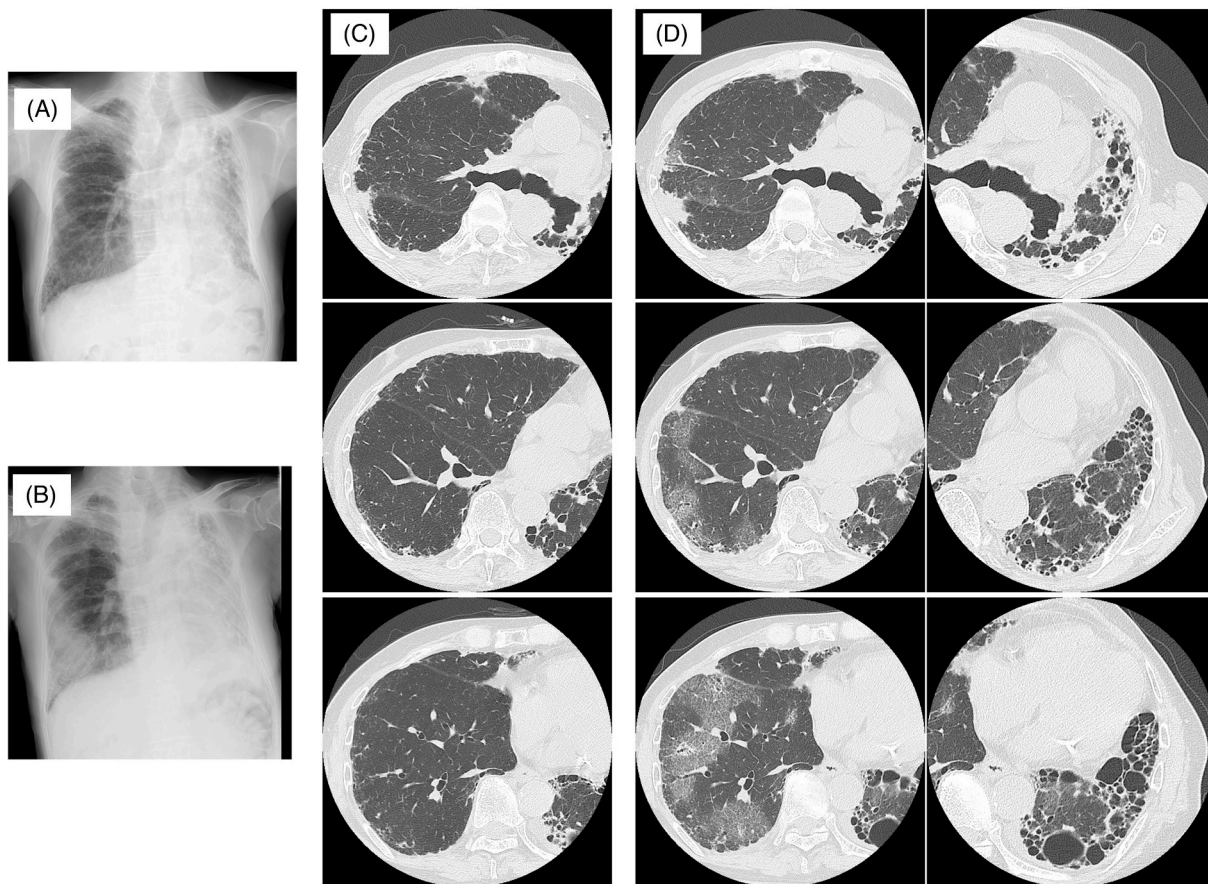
Radiographic images of case #3. Chest X-ray images of the patient (A) before and (B) at the diagnosis of acute exacerbation of interstitial lung disease. Chest CT images of the patient (C) before and (D) at the diagnosis of acute exacerbation of interstitial lung disease.
